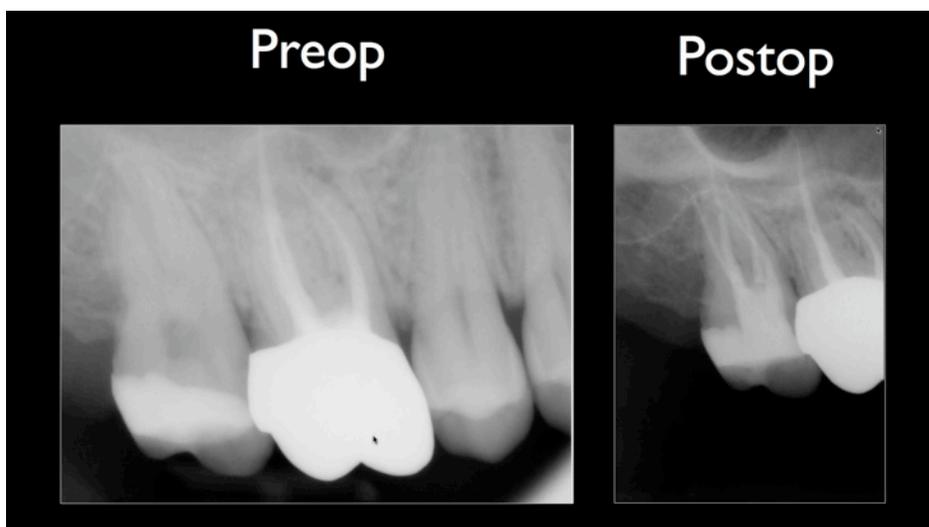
Preoperative and postoperative radiographs of above case.
